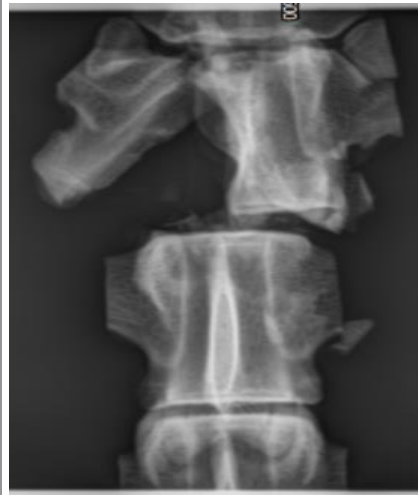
a, b, and c represent the burst fracture of T13, its x-ray image and the force generated to create the fracture respectively. the AP of the x-ray does not appear to show the fracture of the vertebra body.
